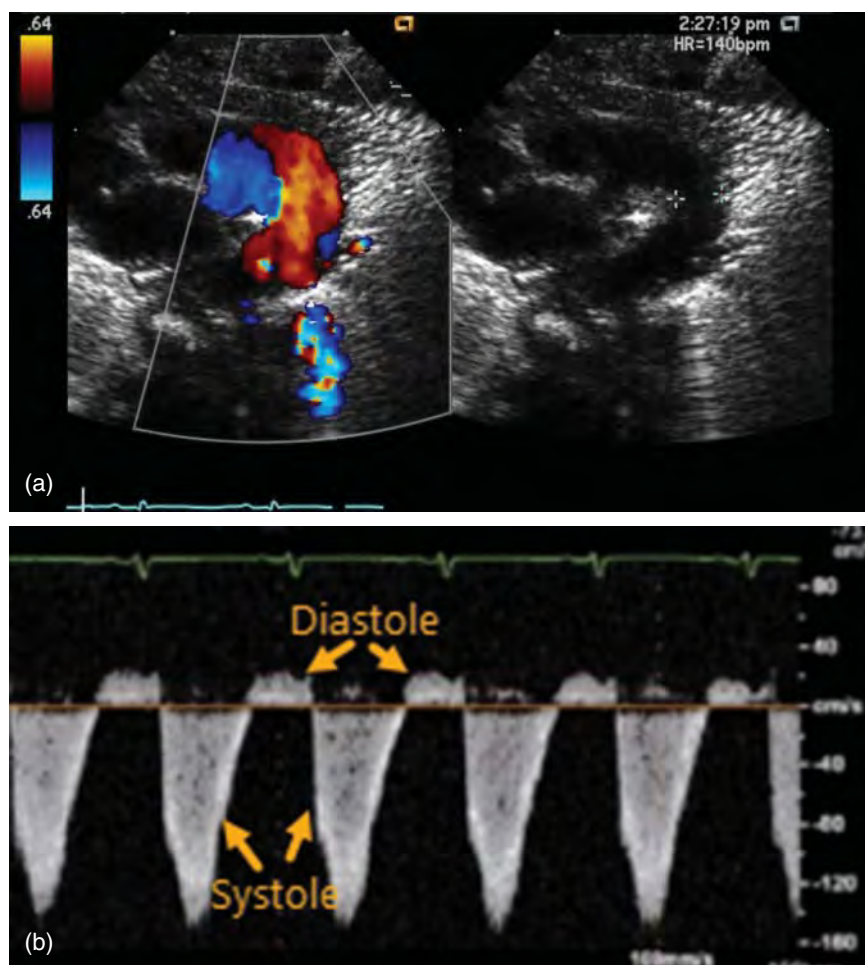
(a) Neonate with a large PDA and with elevated pulmonary resistance. (b) Spectral Doppler image demonstrates bidirectional shunt (right to left during systole and left to right during diastole) but with mainly a systolic shunt.
